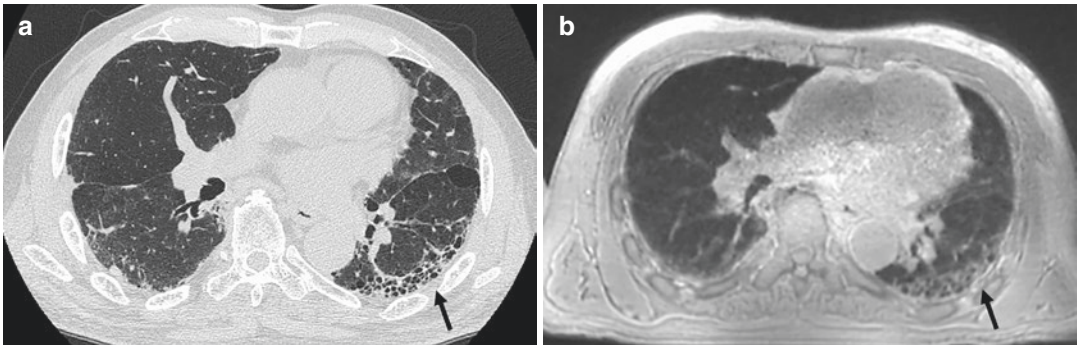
A 82-year-old female patient with UIP. Thin-section CT (a) and thin-section MR imaging with ultrashort TE (b) demonstrate honeycomb lesions (arrows). *Courtesy of Dr. Y. Ohno, Kobe, Japan*
